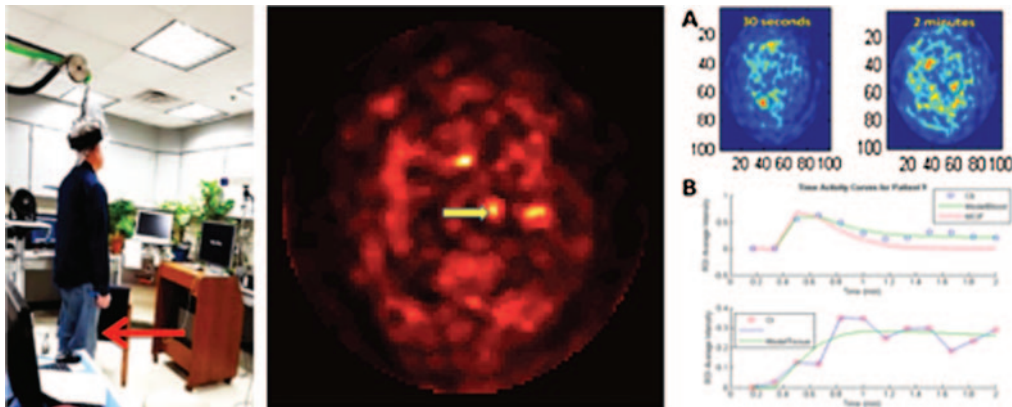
Imaging of the top 4 cm section of the head in the walking experiment, showing selection of the ROI regions for dynamic curve analysis. On the right we show the image used to select the carotid artery (marked with yellow arrow) for input function determination. Demonstration of the analysis using 3-compartment FDG Kinetic Model with formalism developed in the Bijoy Kundu Lab at the University of Virginia simultaneously computed the kinetic parameters and the model corrected blood input function (MCIF) from dynamic FDG images of the brain.
